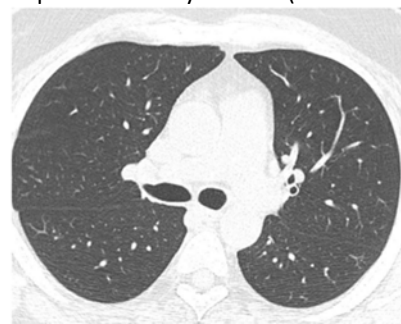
A RTPCR positive female patient aged 41 came with chief complaints of cough showing no CT chest findings.
